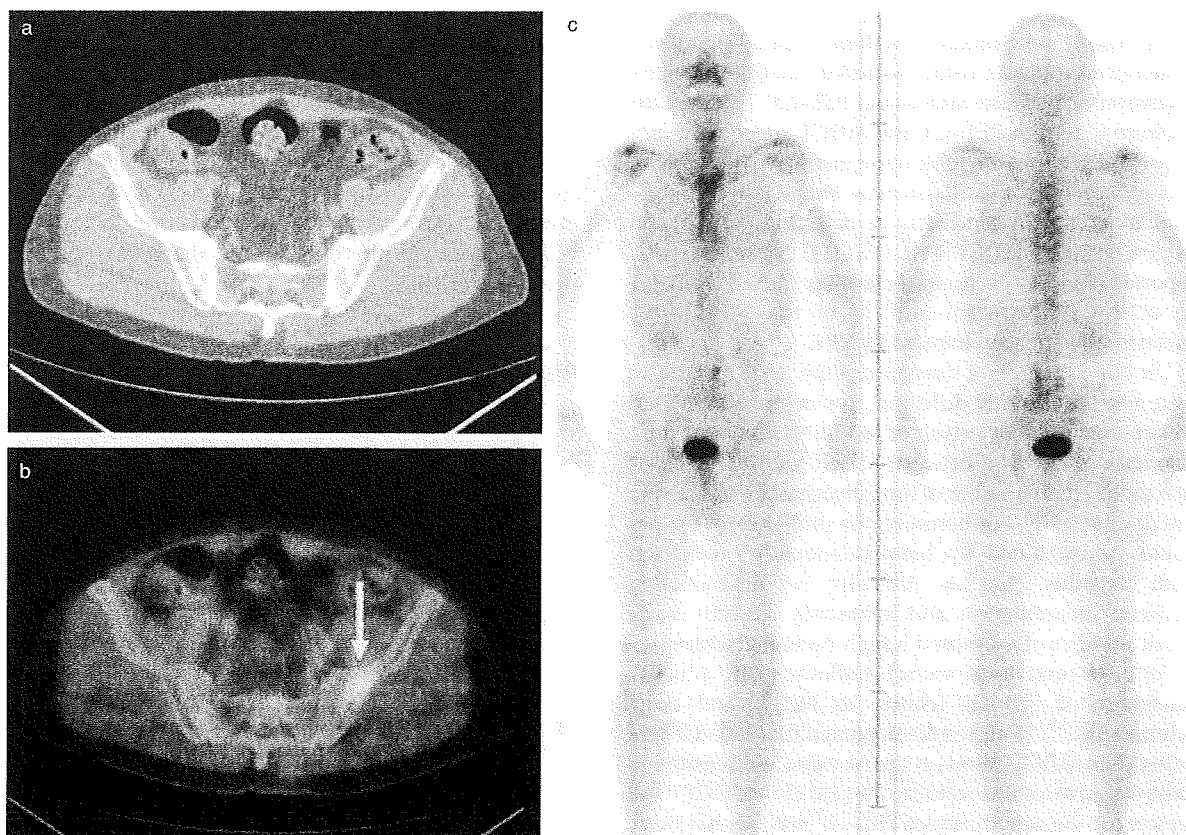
A 76-year-old male patient with hepatocellular carcinoma (HCC). This patient had a bone metastatic lesion measuring 18 mm in diameter in the left iliac bone. (a) The lesion was not detected by multi-detector helical computed tomography (MDCT). (b) The same tumor was clearly detected by positron emission tomography – computed tomography (PET-CT) and showed accumulation of ^{18}F -FDG (SUV = 3.3) (white arrow). (c) The same tumor was not detected by bone scintigraphy.
